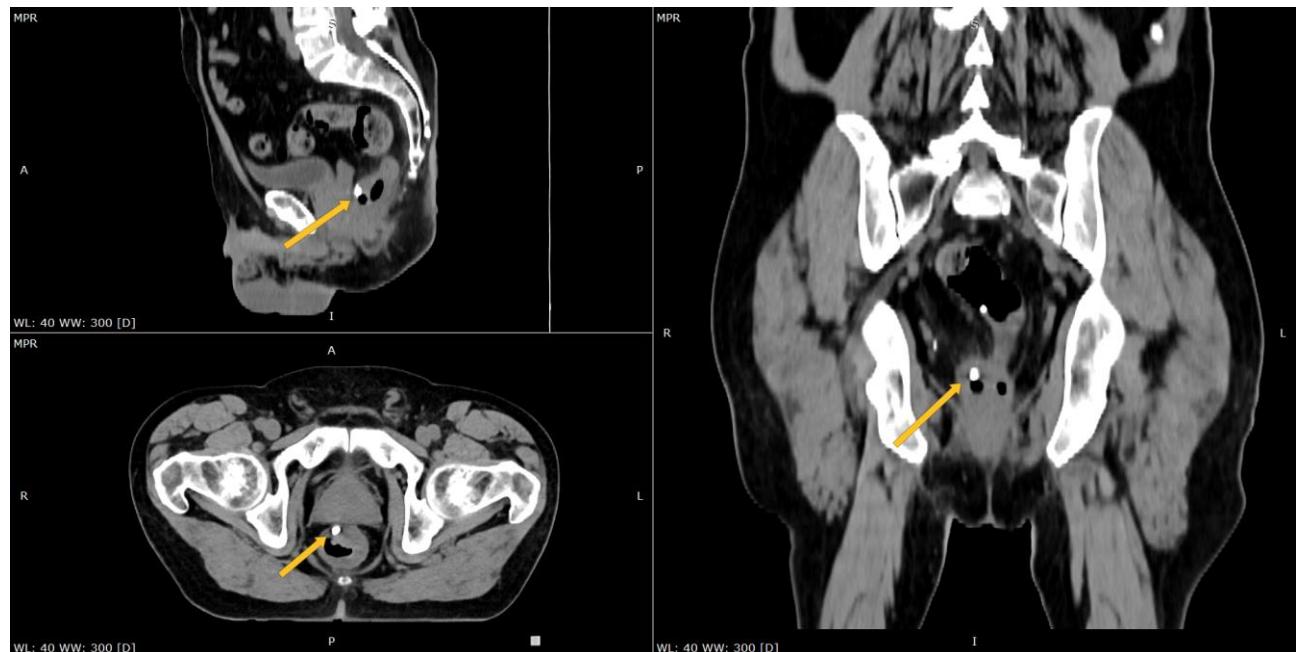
Planning CT showing BioXmark® in the rectal wall of patient with rectal adenocarcinoma.
